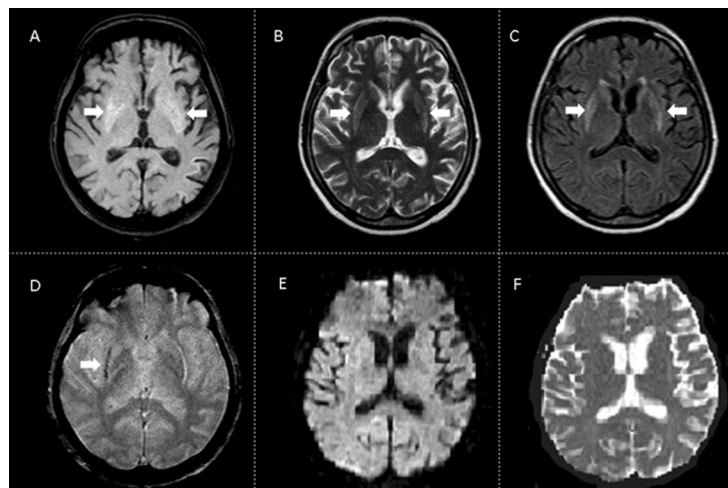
Brain MRI. Panel A shows symmetrical bilateral caudate nuclei and putamina T1 hyperintense signal (white arrows). Panels B and C show bilateral T2 and fluid-attenuated inversion recovery (FLAIR) weighted hyperintensities in the same structures (white arrows). Panel D shows iron deposition in the right external capsule in T2-GRE (white arrow). No restricted water diffusion was shown in DWI/ADC map (Panels E and F). After gadolinium injection, there was no contrast enhancement (image not shown).
